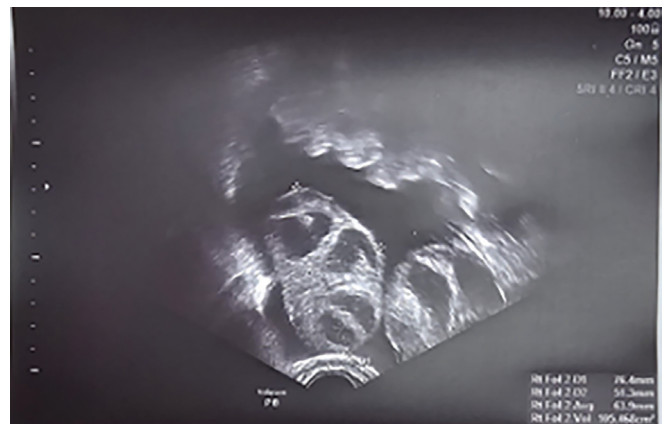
Transvaginal ultrasound image of a patient who developed OHSS. Bilateral ovarian enlargement with multiple cystic follicular structures and free fluid in the pelvis are observed
